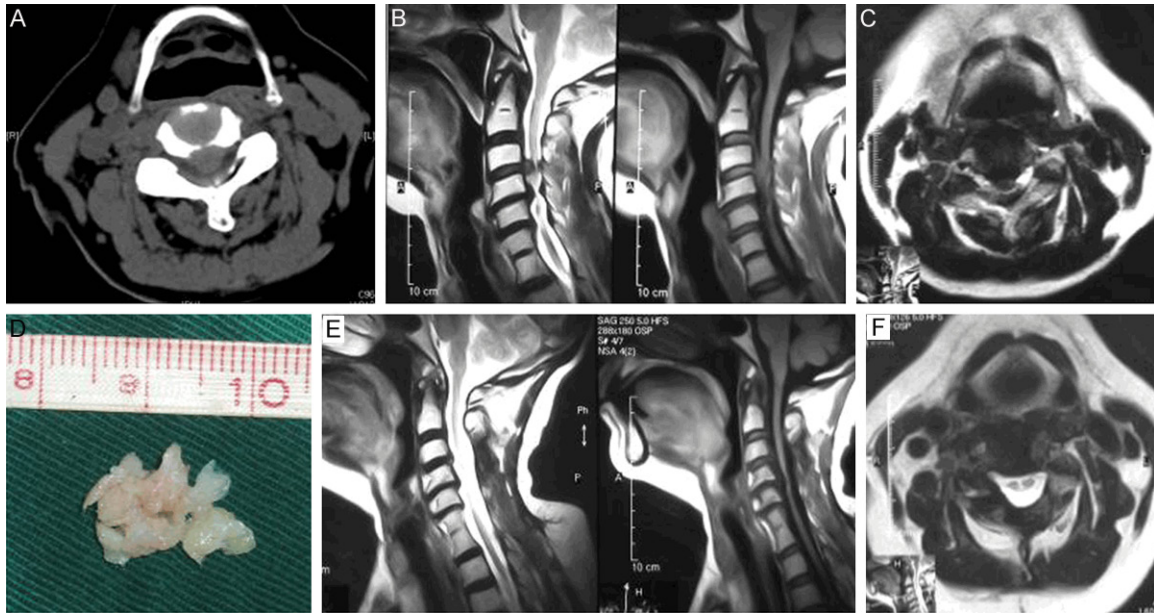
A: With CT image showing C3/4 disc herniation; B: MR image showing cervical stenosis associated with C3/4 disc herniation; C: MR scan showing C3/4 disc herniation; D: Posterior removed C3/4 disc fragments; E: MR scan showing complete anterior and posterior decompression of spinal cord after surgery; F: Postoperative MR image showing the complete removal of C3/4 protruded disc fragments.
